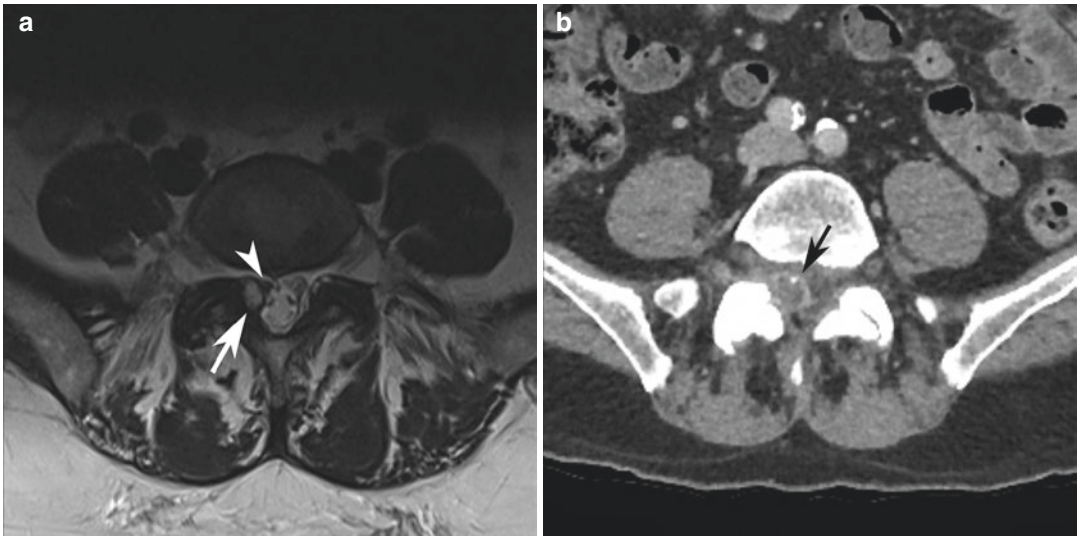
Juxta-articular cysts. Axial T2 WI (a) demonstrates an epidural cystic lesion (a, white arrow) adjacent to an osteoarthritic facet joint. The traversing right nerve root (a, white arrowhead) is mildly displaced. CT image
